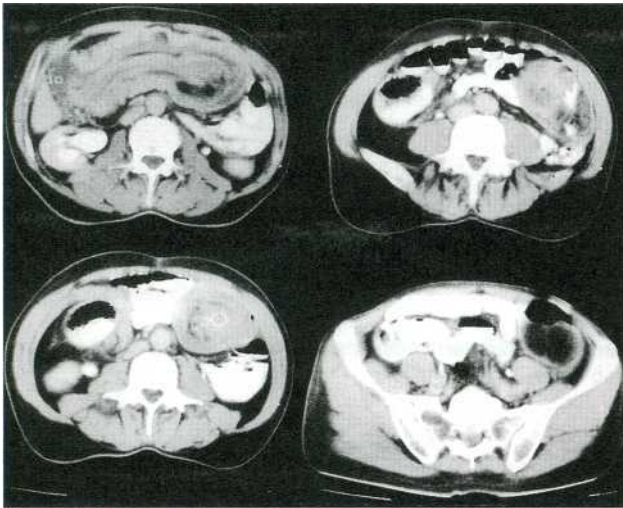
Abdominal CT before the operation: long tract intussusception of the large bowel and tumoral mass in the sigmoid colon
